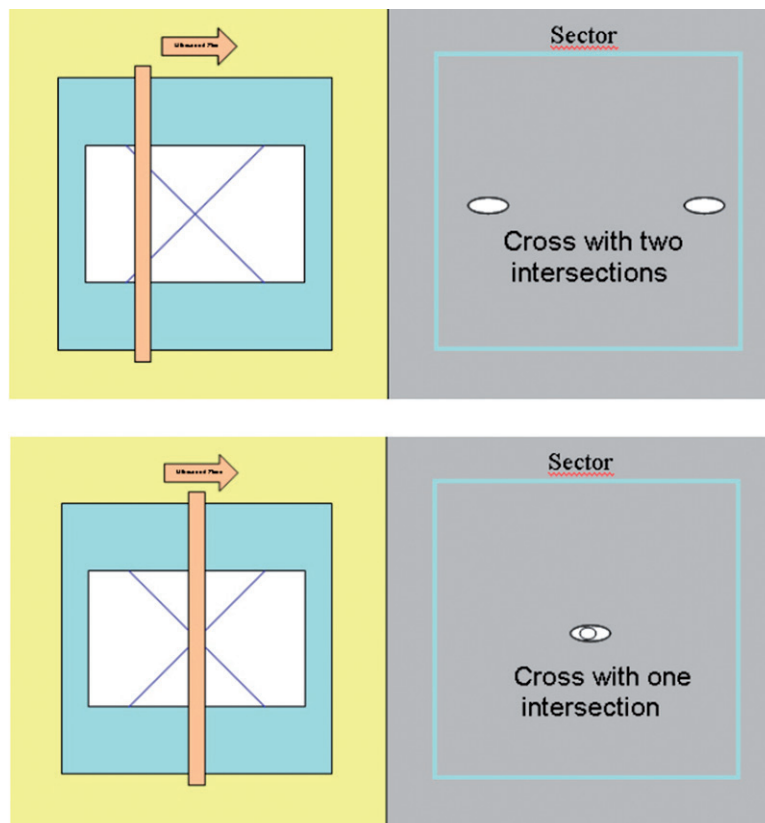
By means of a stepper motor verification device, the ultrasound probe was advanced to the point of intersection of the lines (given geography on a metal plate). In the upper panel the ultrasonic plane does not lie in the intersection region of the lines. In the lower panel the point of intersection has been found.
